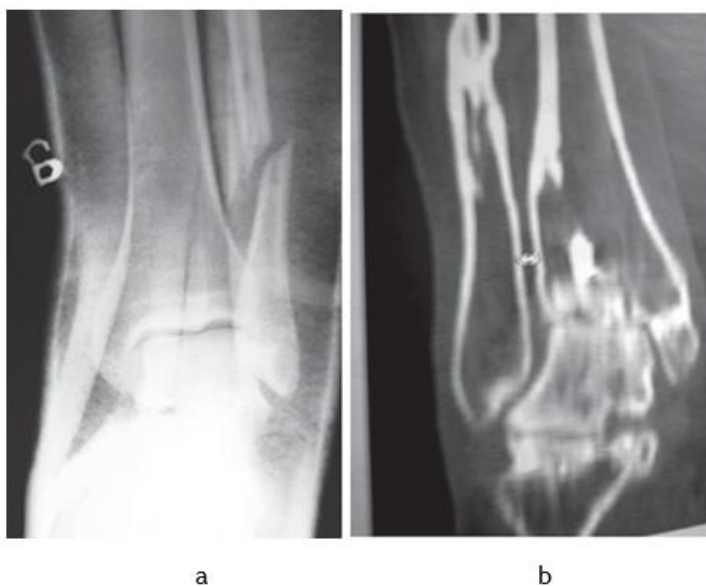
Radiographs (a), spiral CT (b) of the ankle joint of patient M., 42 years old (explanations in the text)
